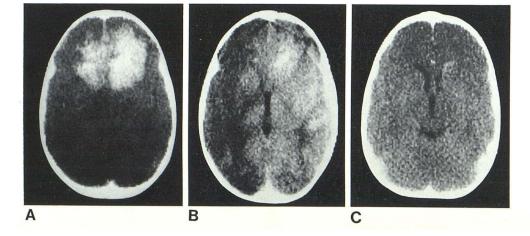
Case 12. Medulloblastoma. Enhanced CT scans. A, At initiation of combination chemotherapy in association with osmotic BBB disruption. B, 2 months later and 30 min after osmotic BBB disruption. Enhancement of entire ispilateral hemisphere and anterior cerebral circulation of contralateral hemisphere. C, Small residual tumor just lateral to right lateral ventricle. This scan, at nearly same level as A, demonstrates massive tumor shrinkage.
